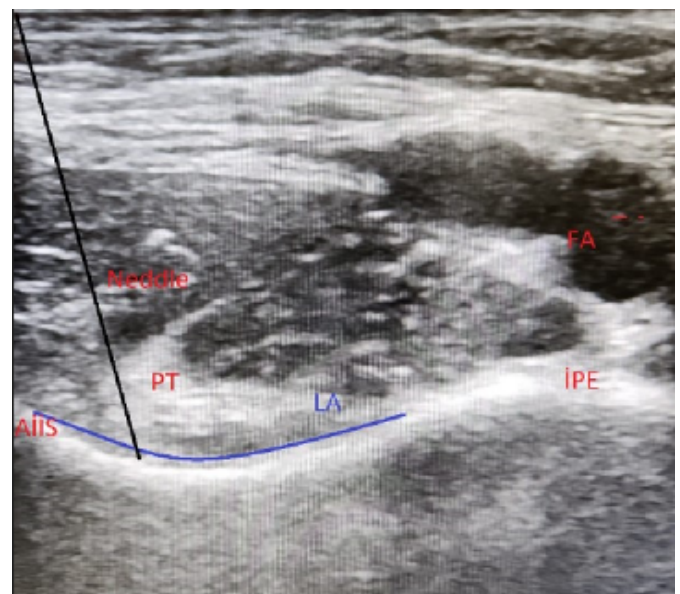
Sonographic view of PENG block. (FA: Femoral artery, PT: Psoas tendon, IPE: Iliopubic eminence, AIIS: Anterior inferior iliac spine, LA: Local anesthetic)
